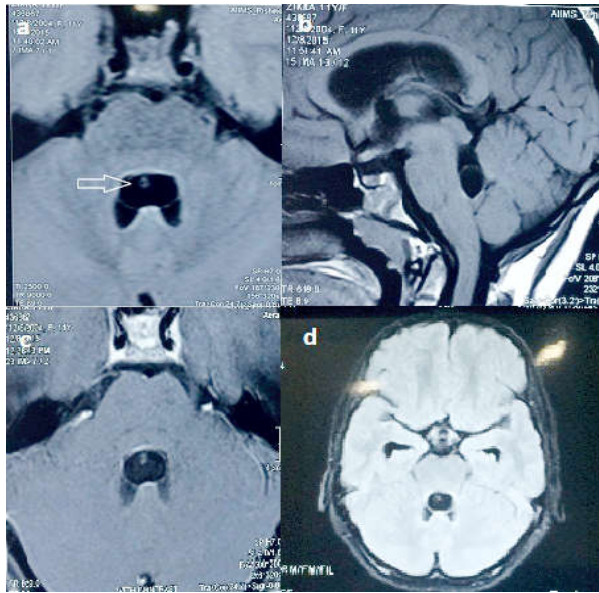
(A-D) Pre operative MRI showing intra 4th ventricular cyst with a nodule inside it. (A) T1 axial image, the arrow points at intracystic nodule (scolex); (B) T1 sagittal; (C) post Gd T1 showing no significant enhancement. The T2 images were essentially non contributory for the intraventricular lesion, hence not shown.
